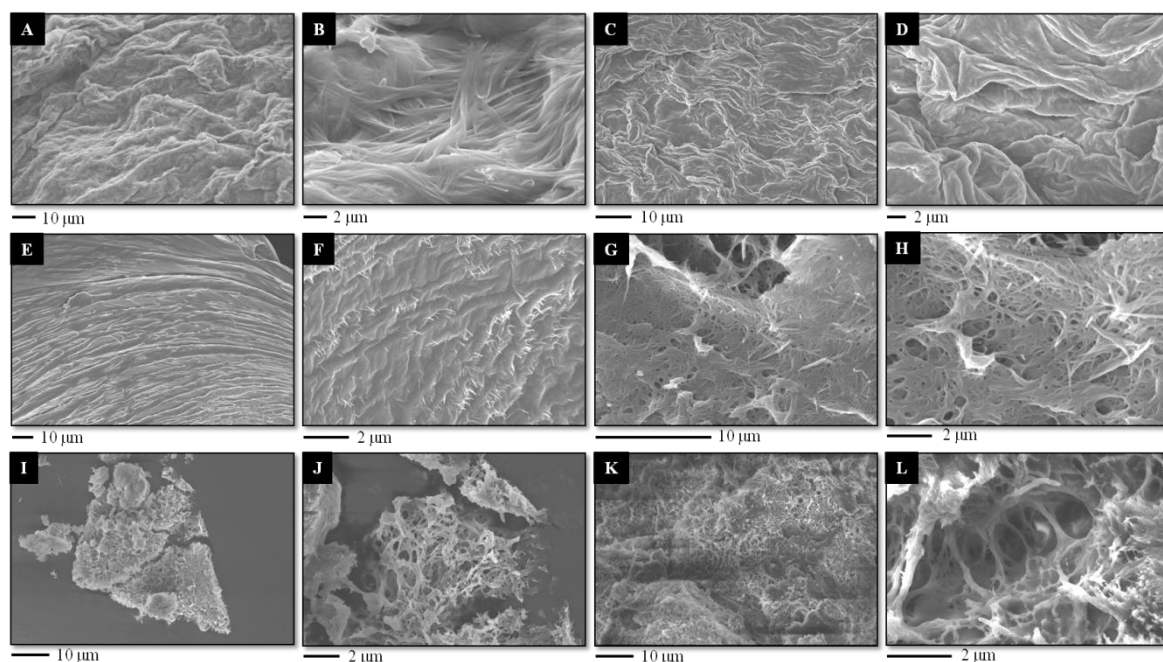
SEM (A, B and G, H) and FESEM (C-F and I-L) images of cryogels prepared by the freeze-drying method from corresponding organogels. A, B: xerogel from toluene (17 mg/mL) prepared by ultrasound treatment; C, D: xerogel from toluene (72 mg/mL) prepared by ultrasound treatment; E, F: xerogel from toluene (72 mg/mL) prepared by classical heating-cooling protocol; G, H: xerogel from MeCN (9 mg/mL) prepared by ultrasound treatment; I, J: xerogel from MeCN (110 mg/mL) prepared by ultrasound treatment; K, L: xerogel from MeCN (110 mg/mL) prepared by classical heating-cooling protocol.
